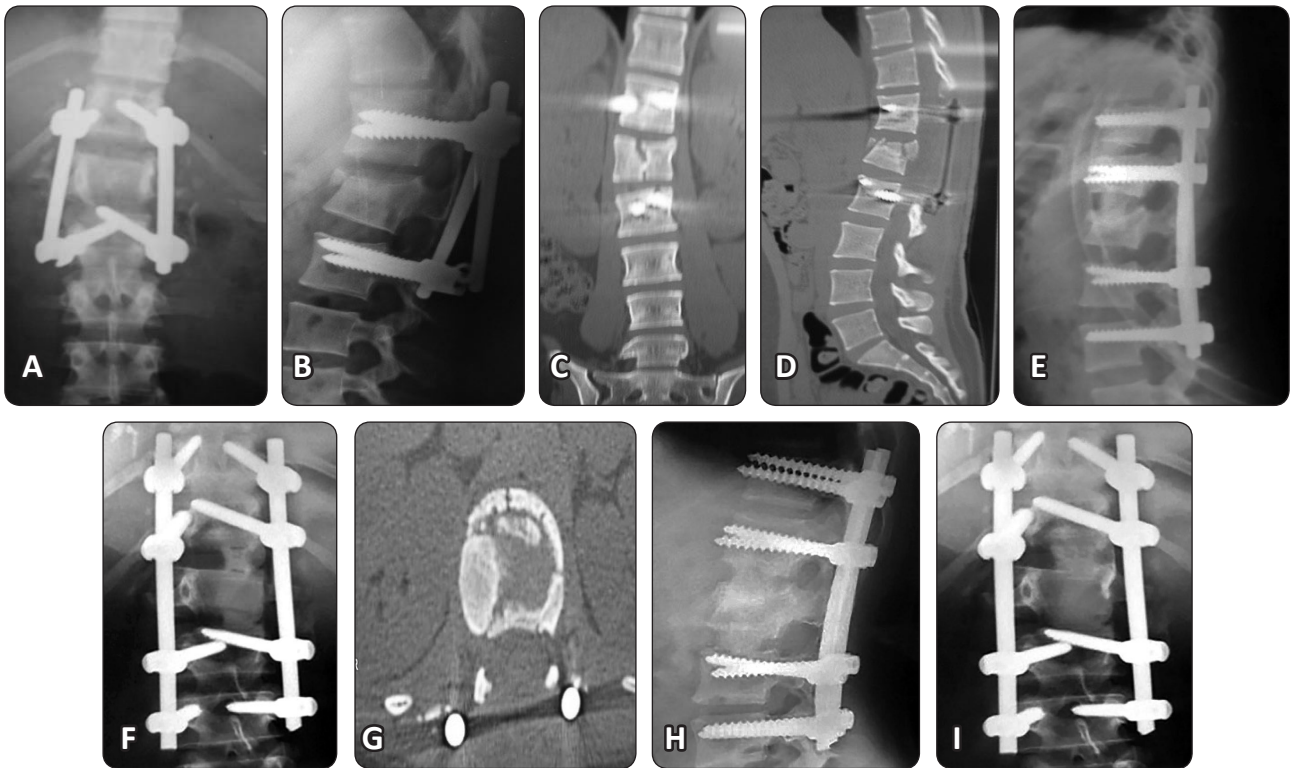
Female patient, 20 years old, Frankel E, with failed short segment pedicular fixation of L1 fracture, 5 months since primary surgery. Preoperative plain X ray: anteroposterior (a) and lateral(b), Preoperative CT: sagittal (c) and axial (d) show pseudoarthrosis. Postoperative plain X ray: anteroposterior (e) and lateral (f) show Posterior long segment pedicular fixation and anterior discectomy of T12 L1 and L1 L2 and strut iliac grafting. Latest follow up plain X ray: anteroposterior (g) and lateral (h) show good fusion.
